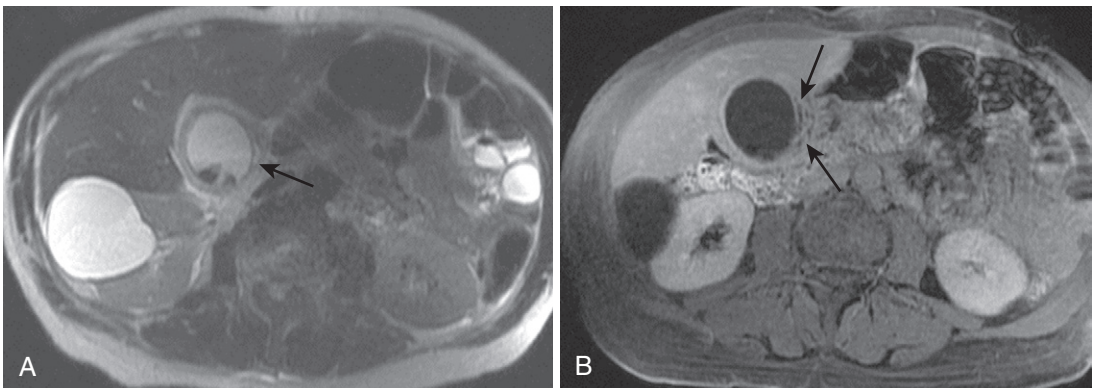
Acute cholecystitis with intramural abscesses. Axial T2-weighted (A) and postcontrast (B) images in a patient with severe acute cholecystitis show gallstones and mural thickening with intramural abscesses (*arrows*).
